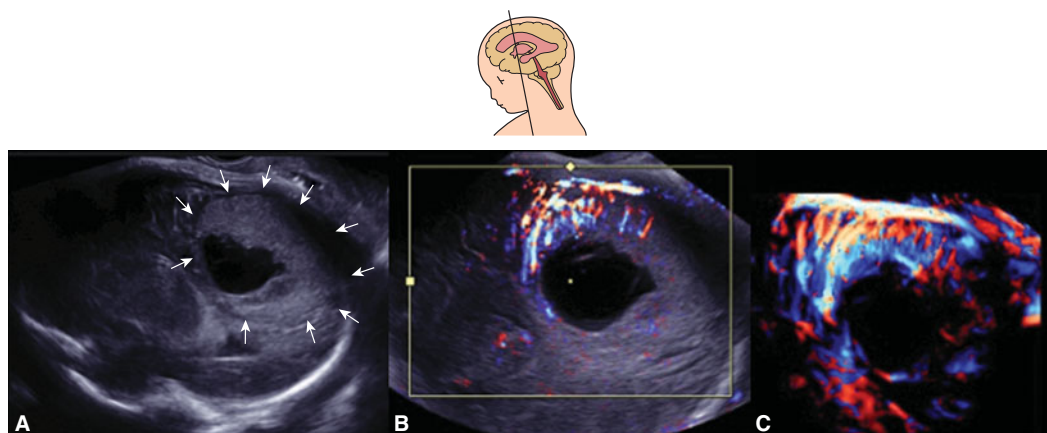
Brain tumor at 40 postmenstrual weeks of gestation. (A) 2D sagittal section. An echogenic mass (arrows) is demonstrated. (B) 2D power Doppler image demonstrating intratumoral vascularity. (C) 3D power Doppler reconstructed angiographic image.
